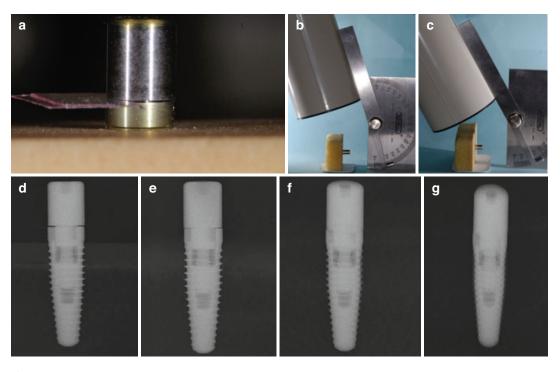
(a–g) These radiographs were made by altering the X-ray cone relative to the implant and healing abutment by (d) 0° , (e) 10° , (f) 20° , and (g) 30° . They show
